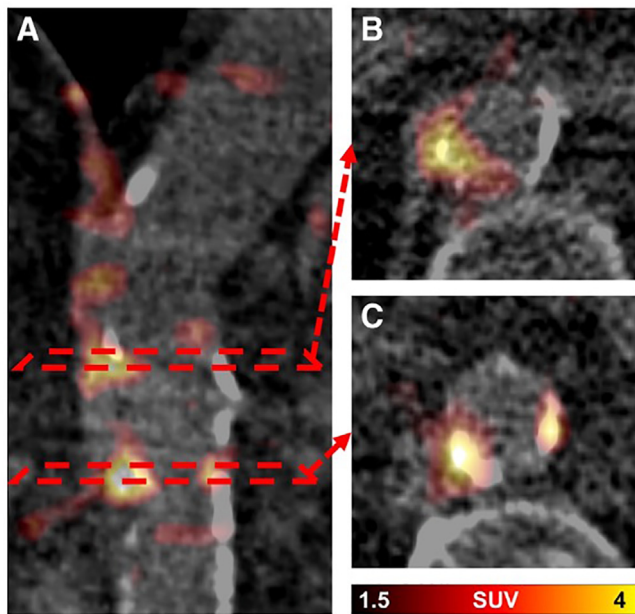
Example of atherosclerotic plaque FAPI uptake. This research was originally published in *EJNMMI*. Kosmala et al. Molecular imaging of arterial fibroblast activation protein: association with calcified plaque burden and cardiovascular risk factors. *Eur J Nucl Med Mol Imaging*. 2023. 50(10); 3011-3021(84). Fused ^{68}Ga -FAPI PET/CT images of patients with aortic valve atherosclerosis. A: Coronal PET-CT image demonstrating 2 major foci of ^{68}Ga -FAPI uptake with corresponding axial images (B and C). B: ^{68}Ga -FAPI uptake exceeds the vessel wall calcification while a further calcified lesion shows no uptake. C: ^{68}Ga -FAPI uptake co-localised well with vessel wall calcifications. FAPI, fibroblast activation protein inhibitors; PET, positron emission tomography; CT, computed tomography.
